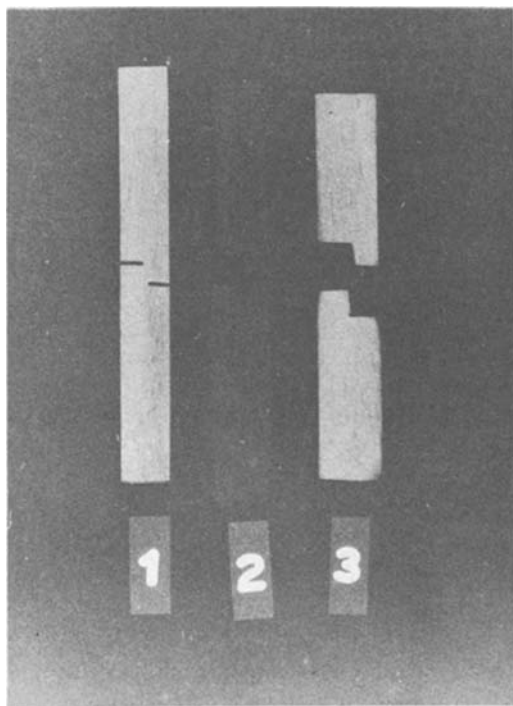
Roentgenogram of representative compact bone samples: (1) untreated bone (before failure); (2) demineralized containing organic component only (after failure); (3) deorganified containing mineral component only (after failure).
